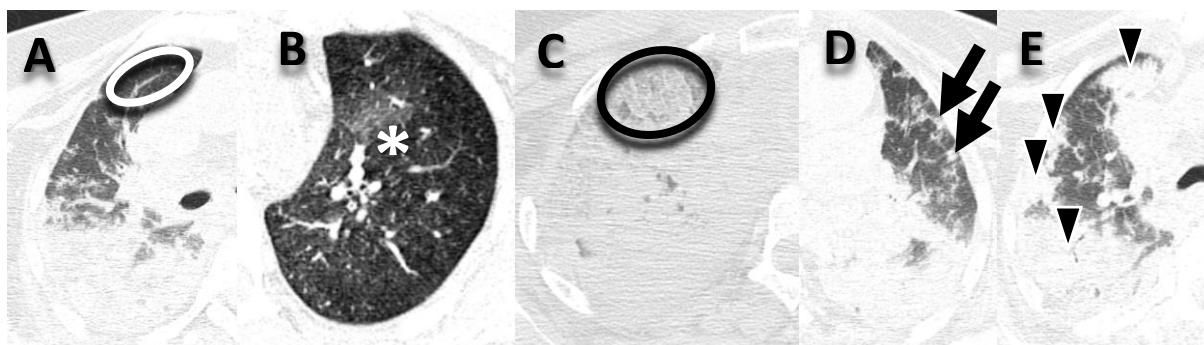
Examples of postmortem CT findings of our sample: A) Normal lung parenchyma (white ellipse). B) Ground-glass opacities (white asterisk). C) Crazy paving (black ellipse). D) Small consolidations (black arrows). E) Large consolidations (black arrowheads).
